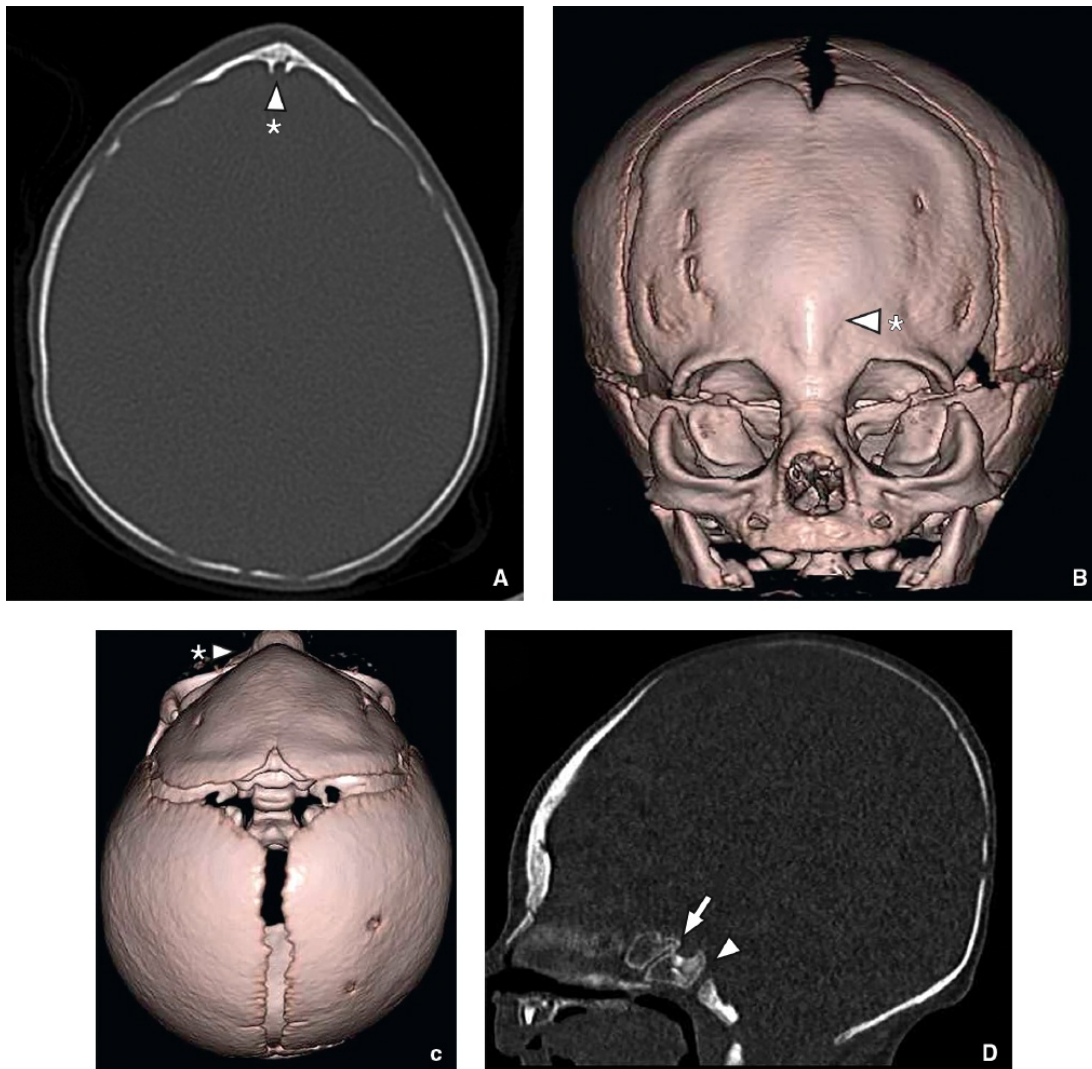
Metopic synostosis in a 24-day-old boy with trigonocephaly. A: Axial bone window CT image confirms trigonocephaly with prominent osseous ridge and metopic notch (*asterisked white arrowhead*) at the site of the prematurely fused metopic suture. B and C: Frontal and superior surface rendering CT images (B and C) show retraction of the medial orbital, hypotelorism, and the contour deformity of the skull. D: Sagittal reformatted CT image demonstrates an incidentally noted persistent craniopharyngeal canal (*arrow*) anterior to the normal spheno-occipital synchondrosis (*arrowhead*).
